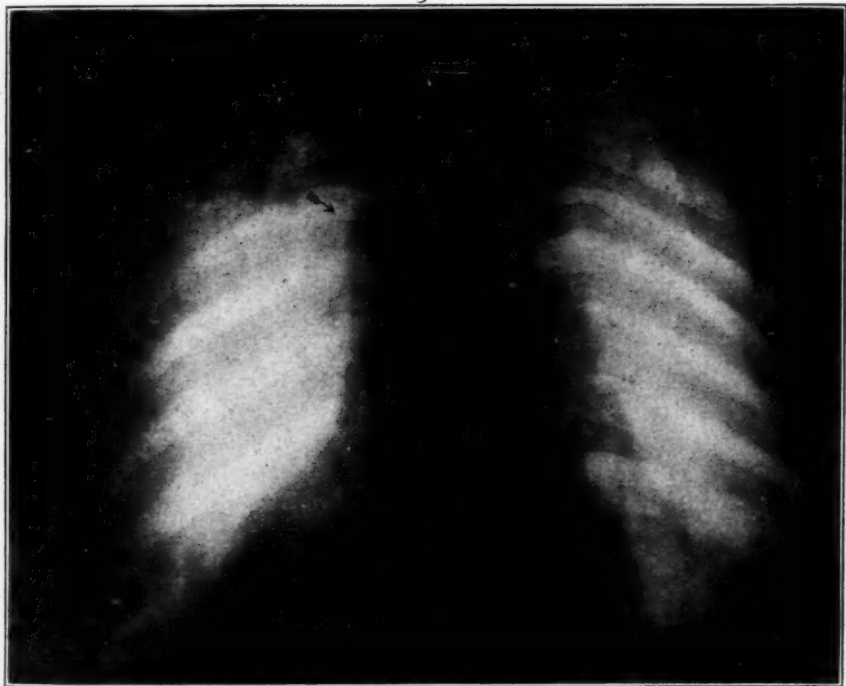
Aneurysm, so small that the radiograph alone would have left it doubtful. Complete paralysis of the left vocal cord and exaggerated bronchial breathing present.
